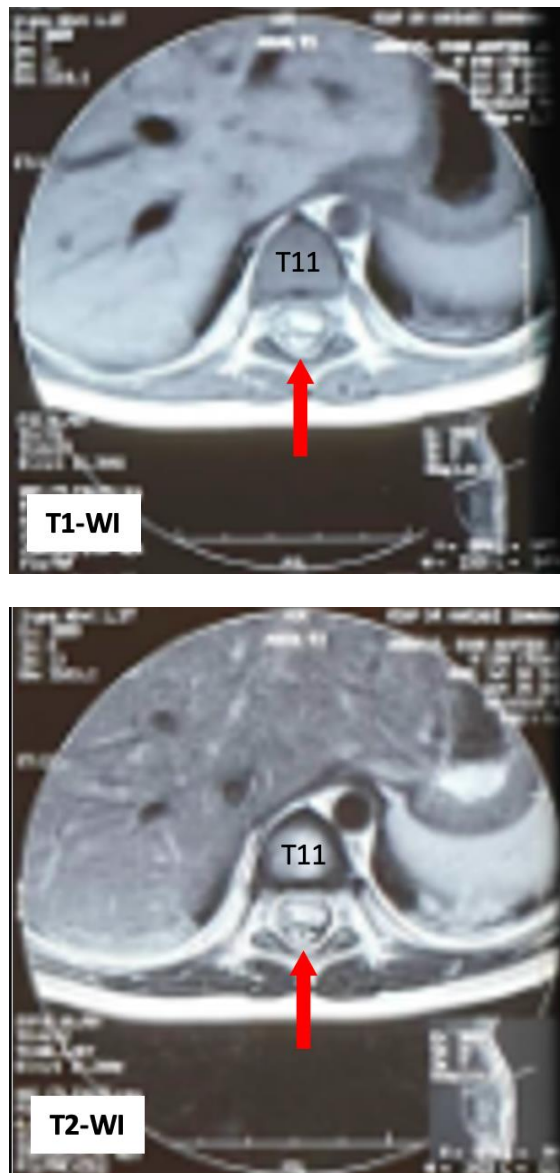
MRI images of an axial section T1-weighted image and T2-weighted image at the T11 level also showed a displacement of the spinal cord to anterior due to the hematoma.
